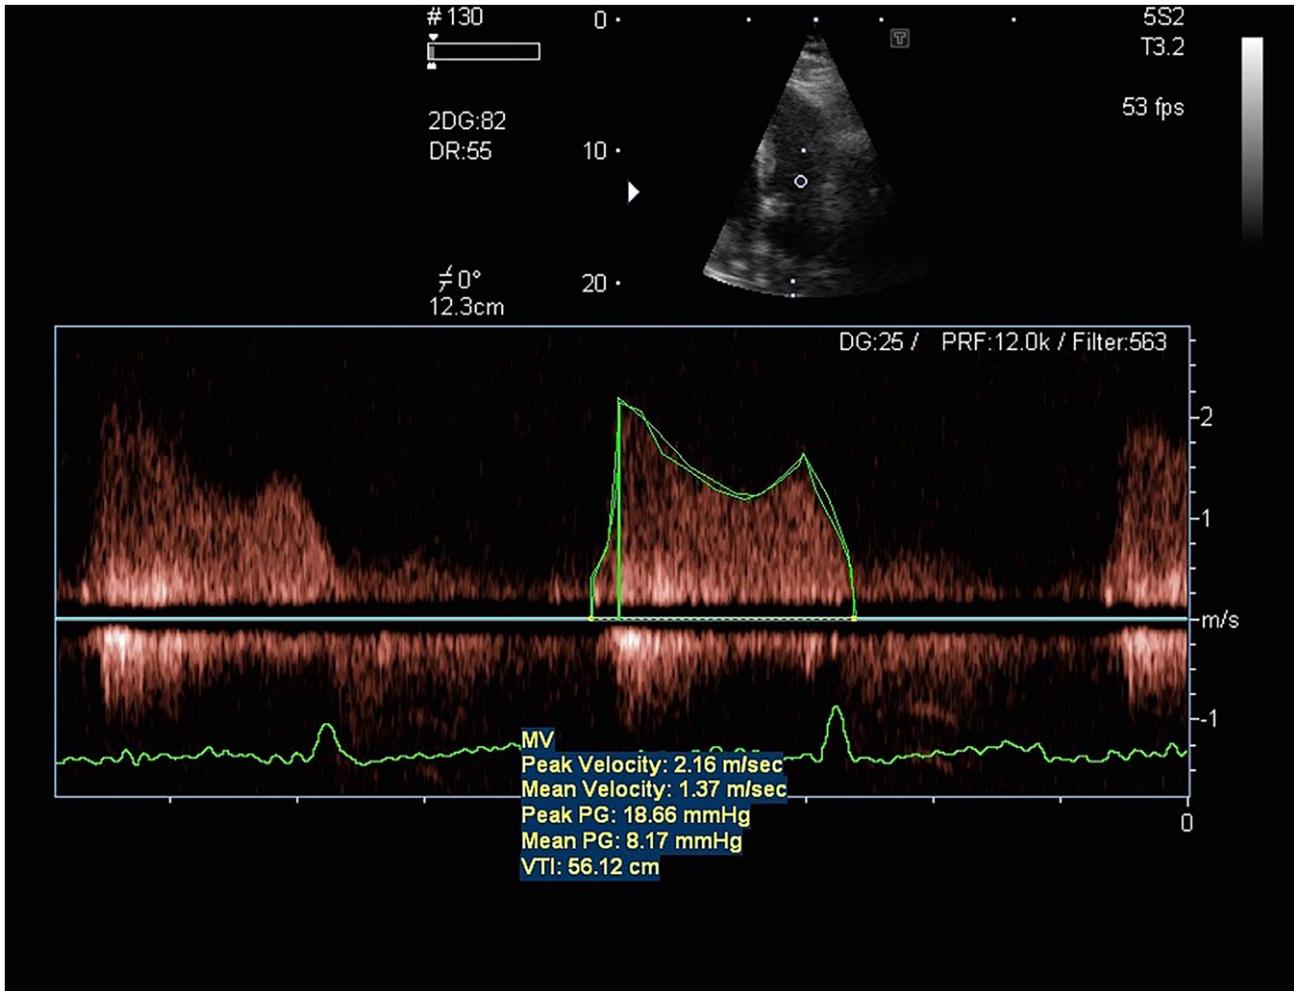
Continuous wave Doppler across the mitral valve (transthoracic echocardiography)
